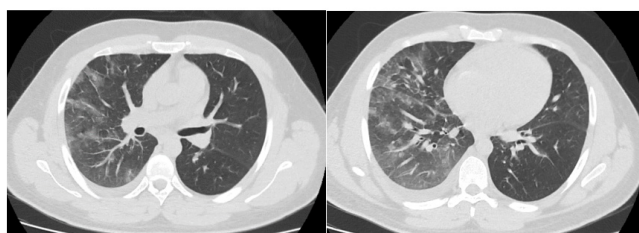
A 24-year-old male patient with COVID-19. The axial non-enhanced CT scan of the chest shows diffuse bilateral patchy areas of GGO with air space opacities peripherally located with interlobar septal thickening, more pronounced at lower lung zones and bilateral pleural effusion.
